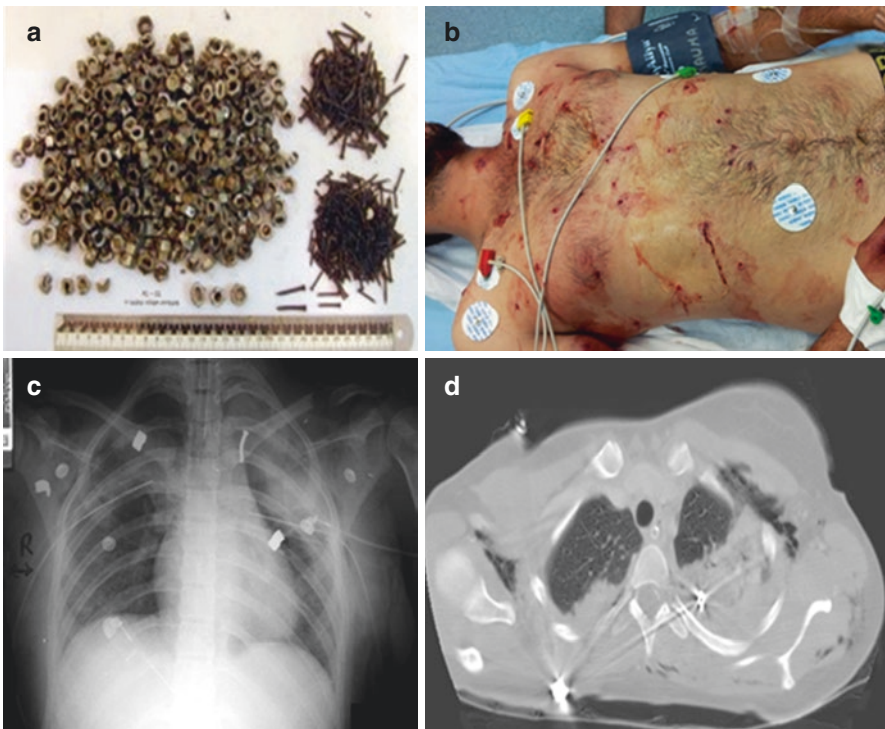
Flying missiles from bombs (a) and multiple skin abrasions caused by small flying objects or debris (b). The same patient's chest X-ray (c) and CT scan show multiple foreign bodies in chest wall and lung (d)
